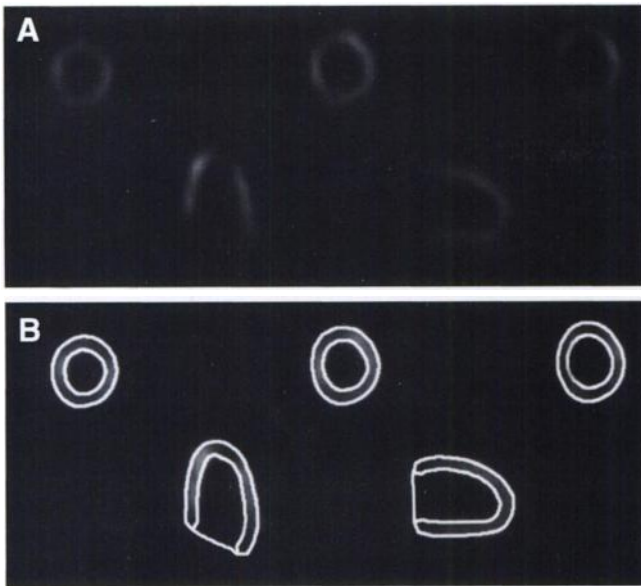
Myocardial contours overlaid by the quantitative gated SPECT algorithm onto three short-axis (top row, left to right = apical, mid and basal) images, a midhorizontal and a midvertical long-axis image (bottom row) of a normal patient at end-diastole. Contour display provides visual evaluation of the algorithm's successful completion. Images corresponding to any of the 8 or 16 gating intervals can be displayed, or cine looping throughout all intervals can be performed in real time.
